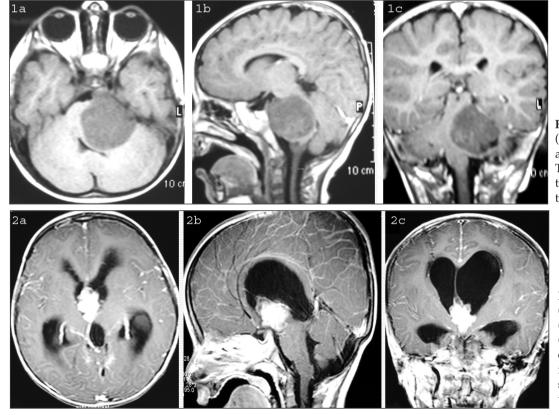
Axial (A), sagittal (B) and coronal (C) T1 MR images of the infratentorial tumor.
